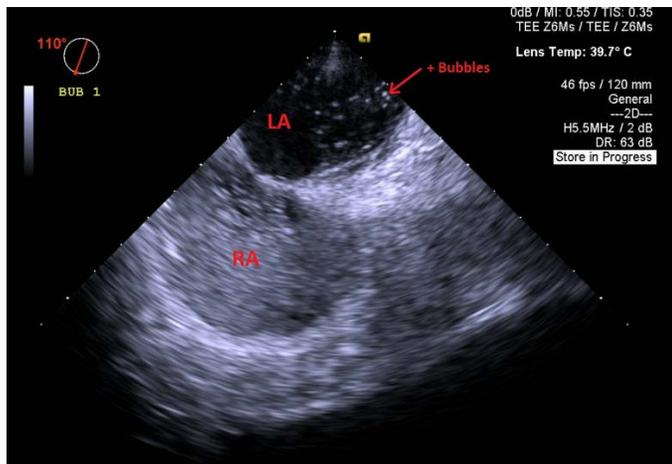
Transesophageal bicaval view during bubble study showing positive late shunting.
